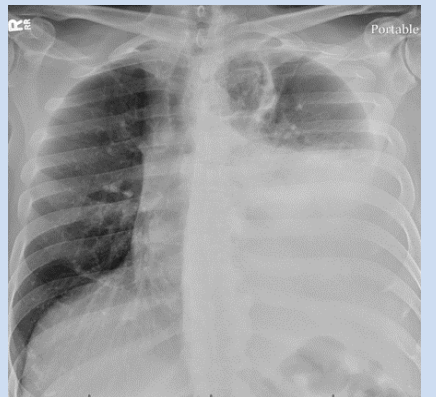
Chest x-ray showing large left-sided pleural effusion with adjacent consolidation and tracheal deviation to the right.
